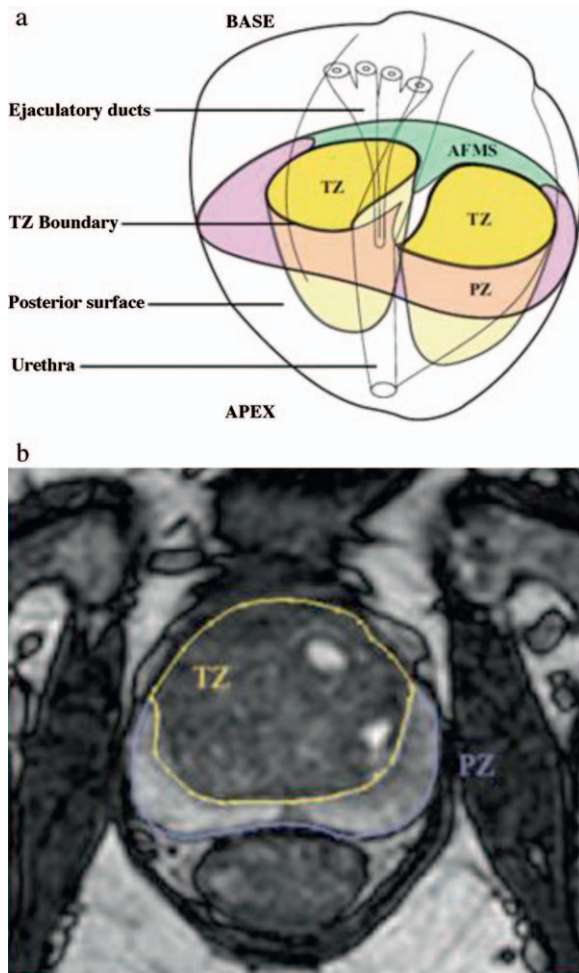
anatomic description (a) and T2-weighted MRI (b) of an average 60cc prostate showing its zonal anatomy with a transverse section at the verumontanum level (TZ: transition zone, PZ: peripheral zone, AFMS: anterior fibromuscular stroma).
